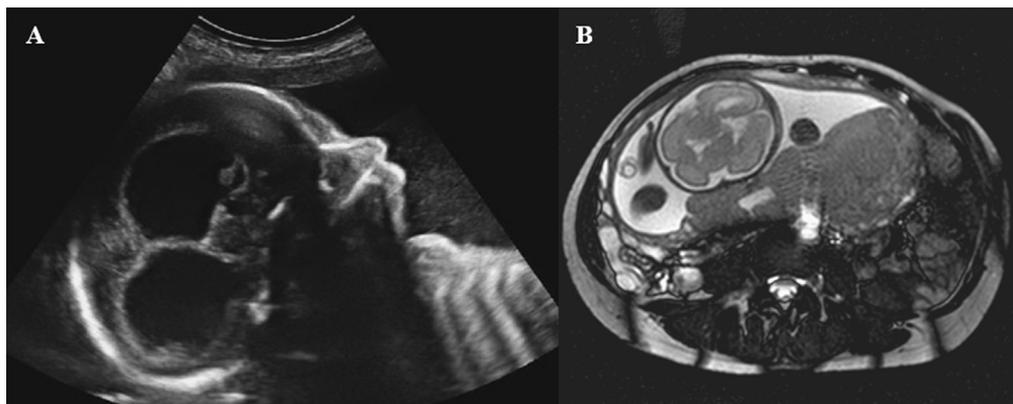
Antenatal detection of FNAIT. A. Ultrasound image of foetal post-haemorrhagic ventriculomegaly, at 28 weeks' gestation, because of foetal alloimmune thrombocytopenia caused by maternal antibodies against HPA-5b. B. Prenatal MR image of a 28-week-old foetus with a parenchymal bleeding in the left parietal region with extension into the cortex. The mother was known to be at risk for FNAIT, with HPA-1a alloantibodies.
